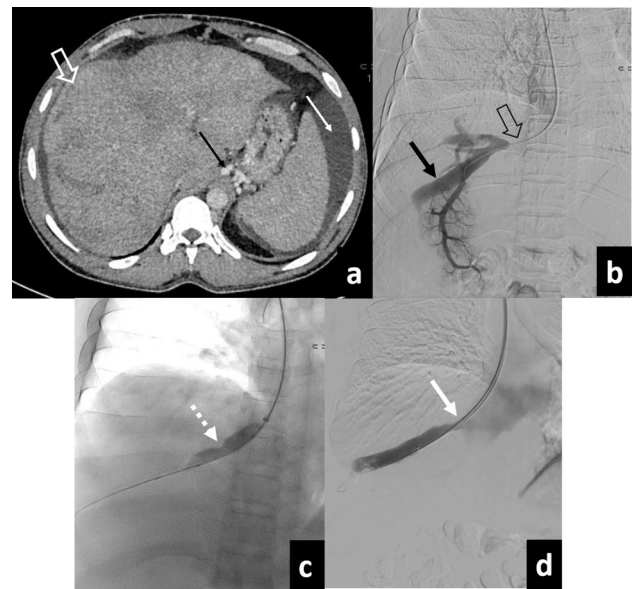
RHV angioplasty for membranous occlusion in a patient with subacute BCS presenting with deranged liver function and ascites. a Axial CECT shows an enlarged and congested liver (open white arrow a). In addition, ascites (thin white arrow a) and lower esophageal venous collaterals (thin black arrow a) are seen, suggesting portal hypertension. b RHV venogram through a transjugular route reveals membranous ostial occlusion of RHV (open black arrow b) with the dilated proximal vein (thick black arrow b). c Obstruction was dilated using a 12 mm balloon (dash white arrow c). d Post-angioplasty venogram showing free flow (thick white arrow d) across the stenotic segment into IVC RHV Right hepatic vein, CECT Contrast-enhanced CT, IVC Inferior vena cava
